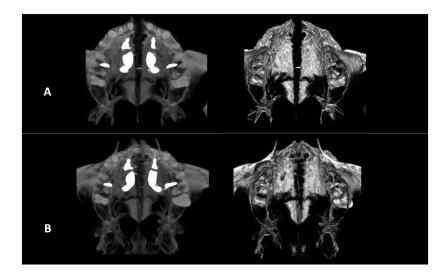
A and B, Postexpansion and posttreatment CBCT images show that midpalatal suture ossification was still incomplete.
